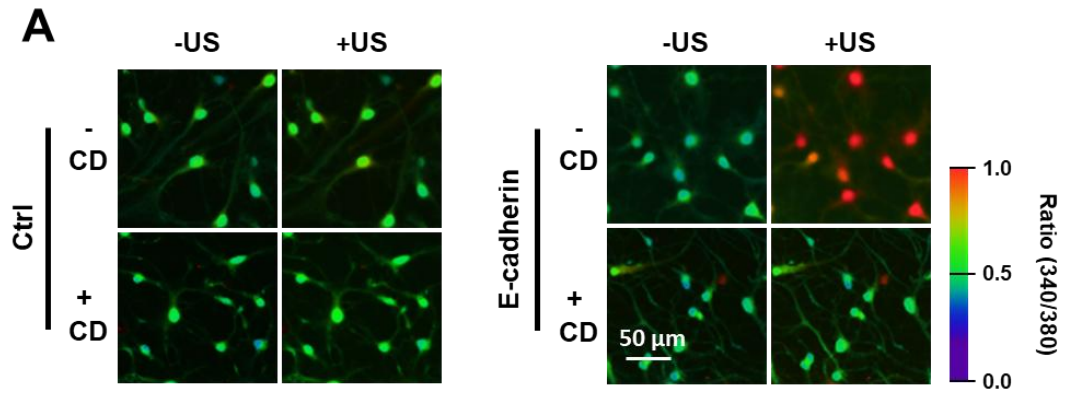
E-cadherin mediates ultrasound-induced Ca^{2+} influx in primary neurons.
